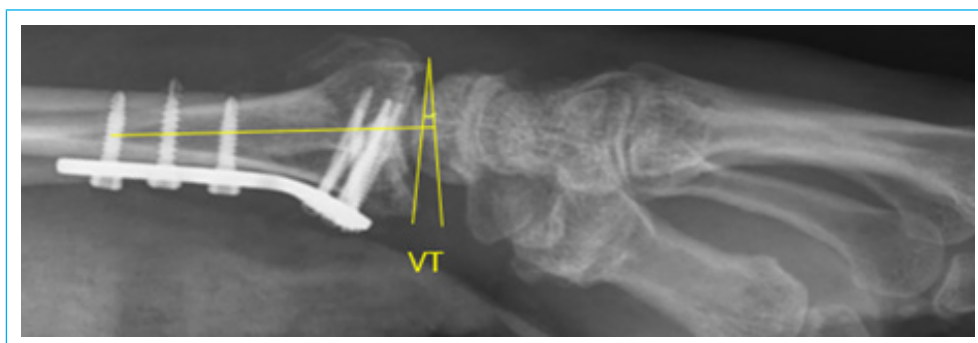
Measurement of volar tilt on the lateral wrist radiograph. VT: Volar Tilt.
